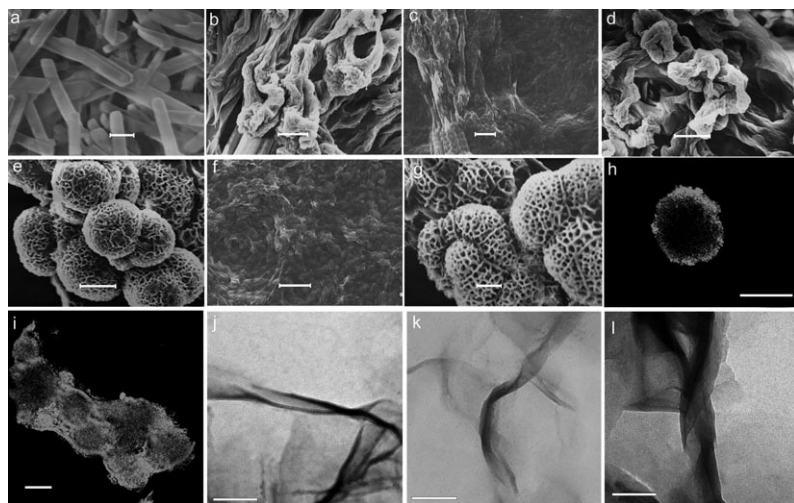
SEM images of the xerogels from the 1b S gel (a, 30 mg mL⁻¹ in *n*-butanol, ultrasonic treatment: 0.16 W cm⁻², 40 KHz, 5 min); 1c T gel (b), S gel (c, ultrasonic treatment: 0.16 W cm⁻², 40 KHz, 30 s), and R gel (d) in *n*-butanol (10 mg mL⁻¹); 1c T gel (e), S gel (f, ultrasonic treatment: 0.16 W cm⁻², 40 KHz, 30 s), and R gel (g) in *p*-xylene (15 mg mL⁻¹). CLSM images of the xerogel skeleton of the 1c T gel (h) and S gel (i) in *p*-xylene. TEM images of the 1c T gel (j), S gel (k), and R gel (l) in *p*-xylene. Scale bars: 2 μm (a), 10 μm (b), 5 μm (c), 10 μm (d,e), 20 μm (f), 10 μm (g), 20 μm (h,i), 100 nm (j,k,l).
